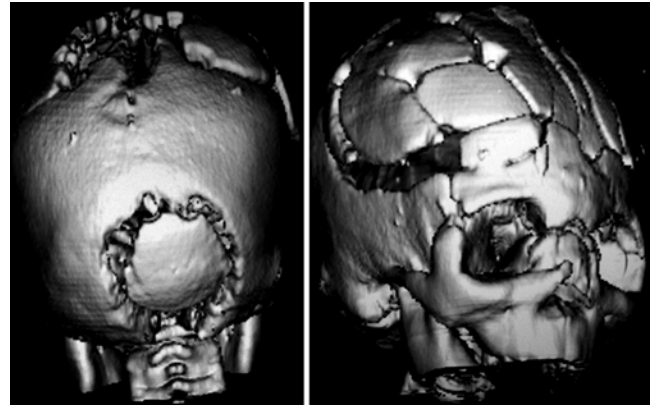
Case 2. Three-dimensional cranial CT scans showing bilateral osteotomies in frontal, parietal, and temporal bones, orbital bar advancement, and superior sagittal sinus decompression (left), as well as surgical decompression of the posterior fossa (right).
